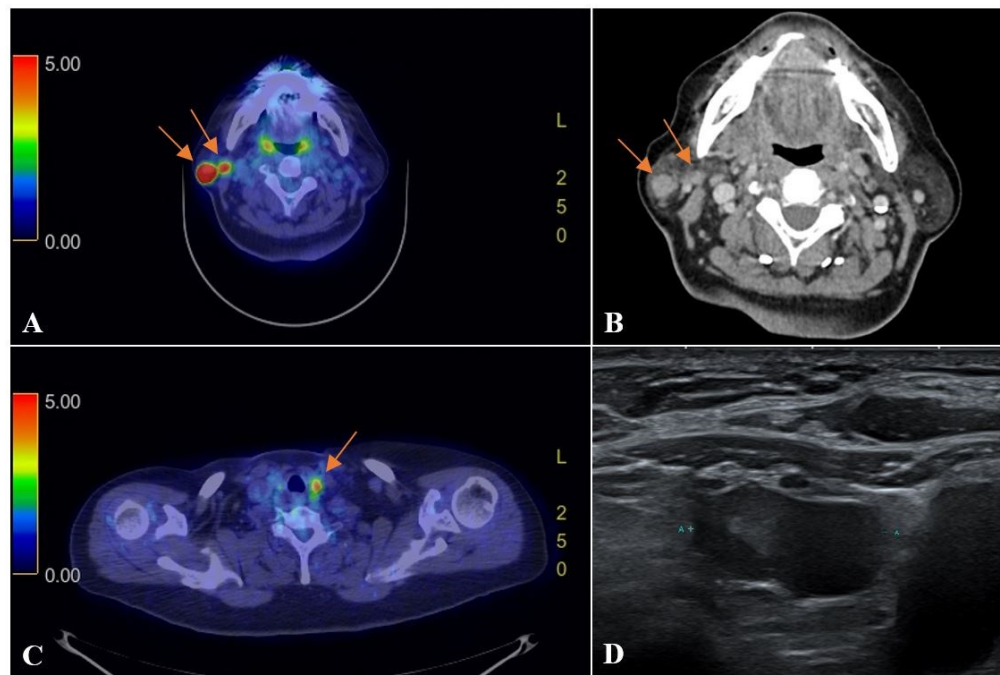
[¹⁸F]FDG PET/CT reveals incidental hypermetabolic parotid nodules (SUVmax of 73.3) (A) and a hypermetabolic left thyroid nodule (SUVmax of 5.2) (C). Neck CT shows well-defined enhancing nodules in the parotid gland (B), which were considered as Warthin's tumors by fine needle aspiration. USG shows a mainly cystic nodule with low suspicion in the left thyroid lobe (D)
